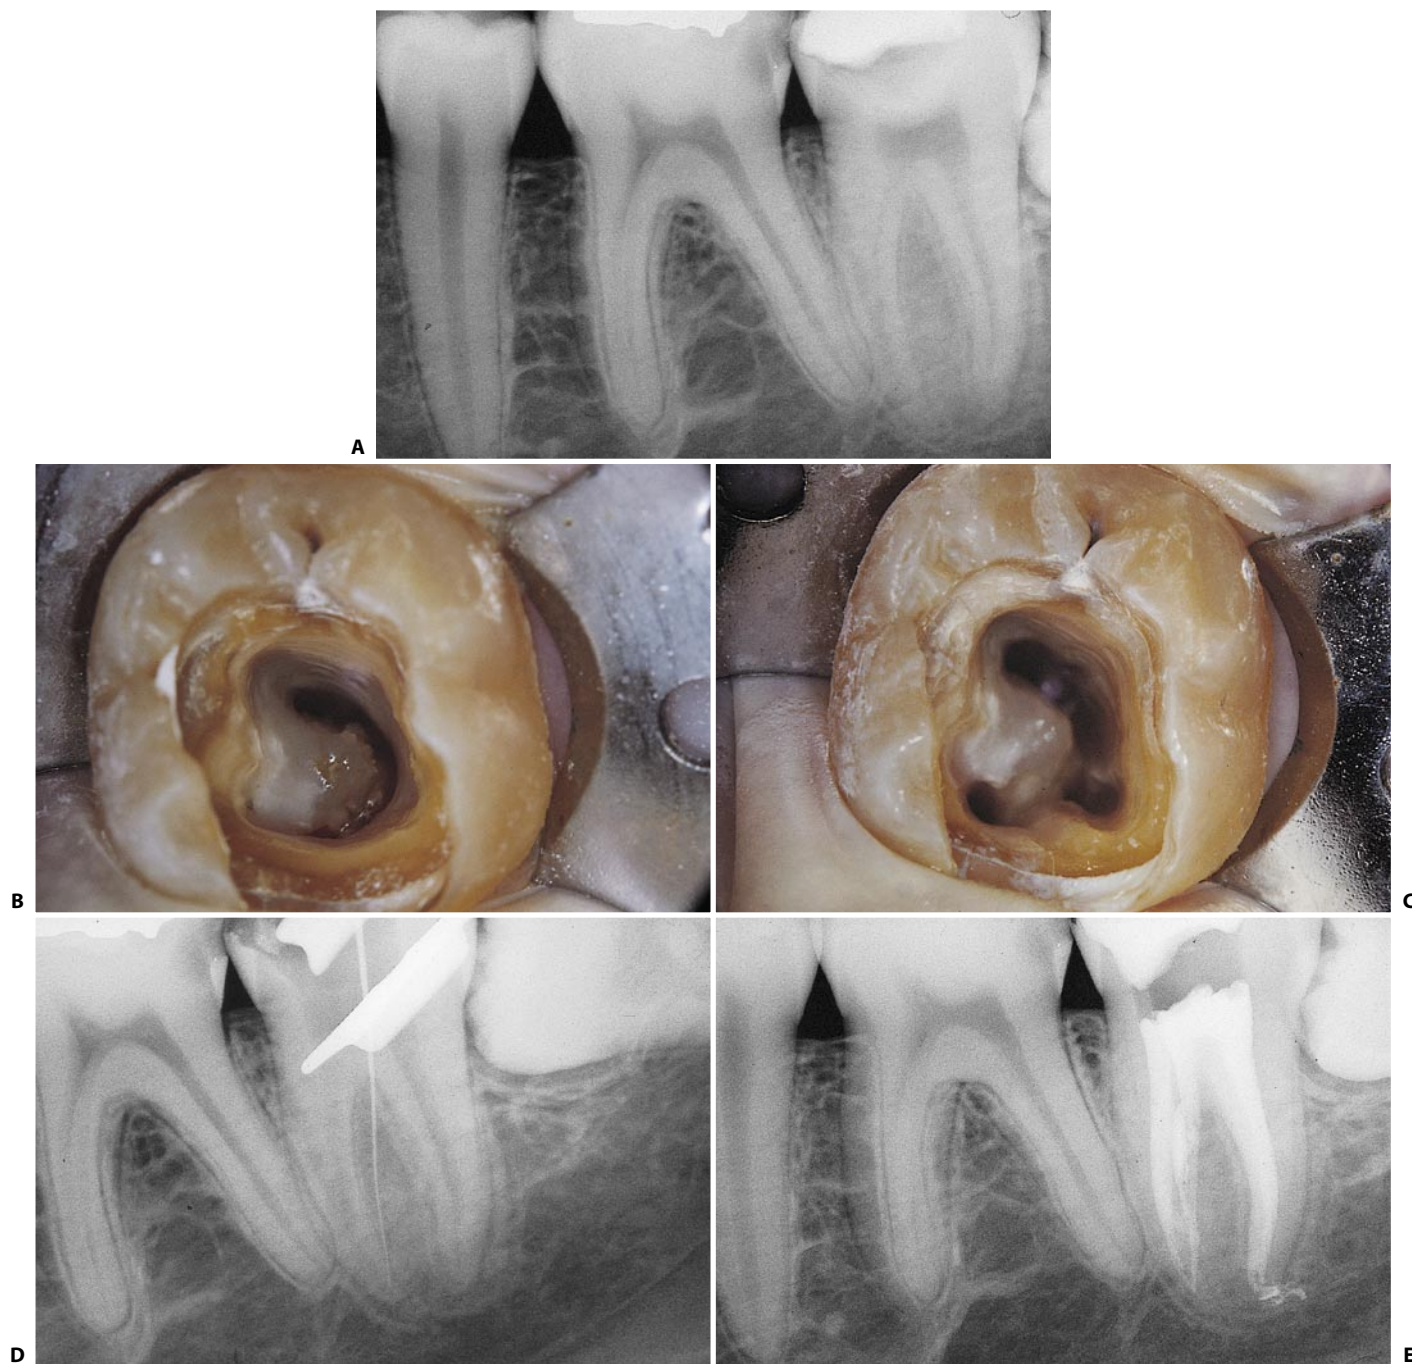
A lower left second molar with an incomplete C-shaped canal. A. Preoperative radiograph. B. Access cavity: the three canals appear to be joined by a groove with a buccal convexity. A C-shaped canal was diagnosed. C. After completing the cleaning and shaping phases, the "C" appears incomplete, as it involves only the distal and mesiobuccal canals. D. An instrument introduced into the mesiobuccal canal indicates the confluence of this canal with the mesiolingual canal. E. Postoperative radiograph.
